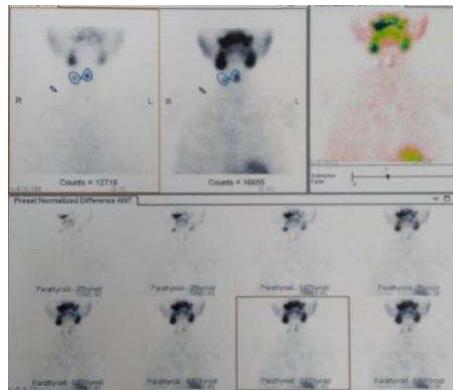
Parathyroid scintigraphy
